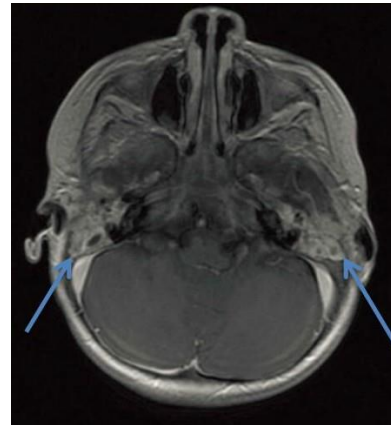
Post-contrast axial MRI (series 3, image 15) with debris in the bilateral mastoid air spaces leading to loss of pneumatization (arrows), consistent with mastoiditis.
